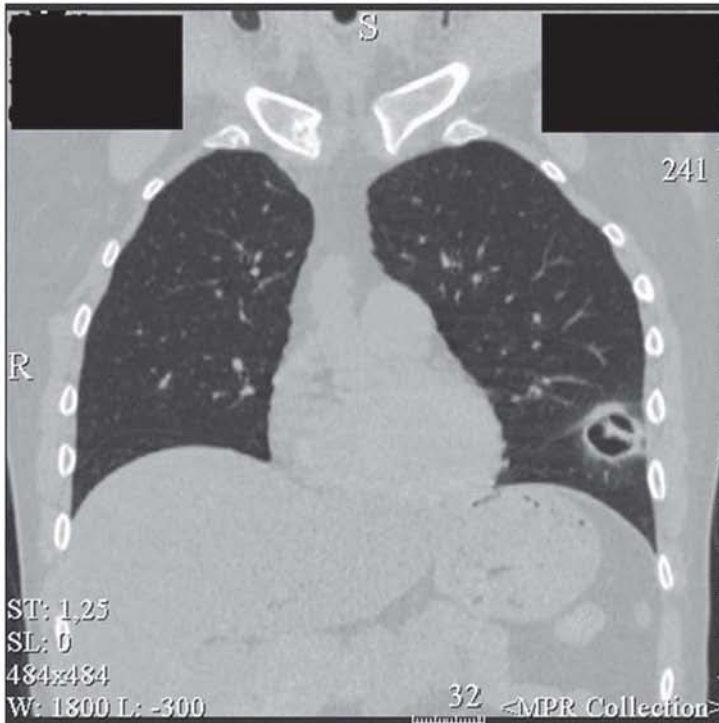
Thoracic CT-scan image of a patient with a probable invasive aspergillosis
